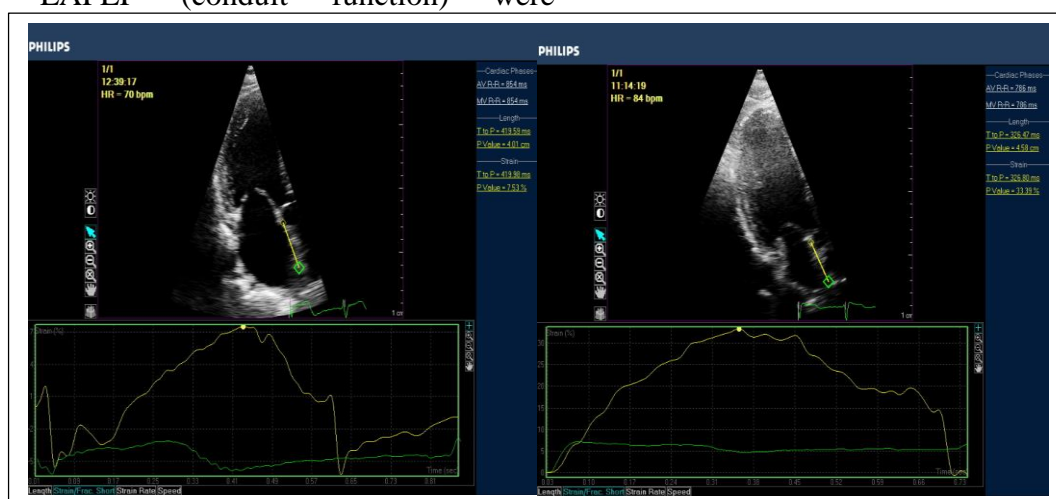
Two-dimensional echocardiography apical two-chamber view showing the LA anterior wall peak strain in patient with DCM (left, a 57 years old patient, NYHA class III-IV, EF=43%, peak LA anterior wall strain= 7%. Right, a 57 years old patient, NYHA class I-II, EF=43%, peak LA anterior wall strain= 32%)
